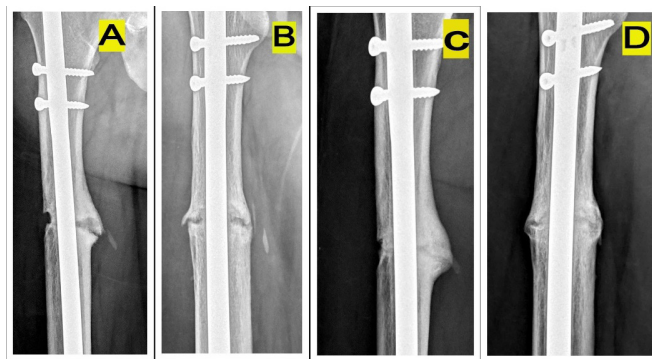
(A, B) Anteroposterior and lateral radiograph of a 42-year-old patient with impaired fracture healing of left subtrochanteric femur fracture inspite of two surgeries and bone grafting, (C, D) radiographs at 3 months showing bridging callus formation across the fracture ends after denosumab therapy, (E, F) radiographs at 6 months postdenosumab therapy showing complete union of the fracture.
